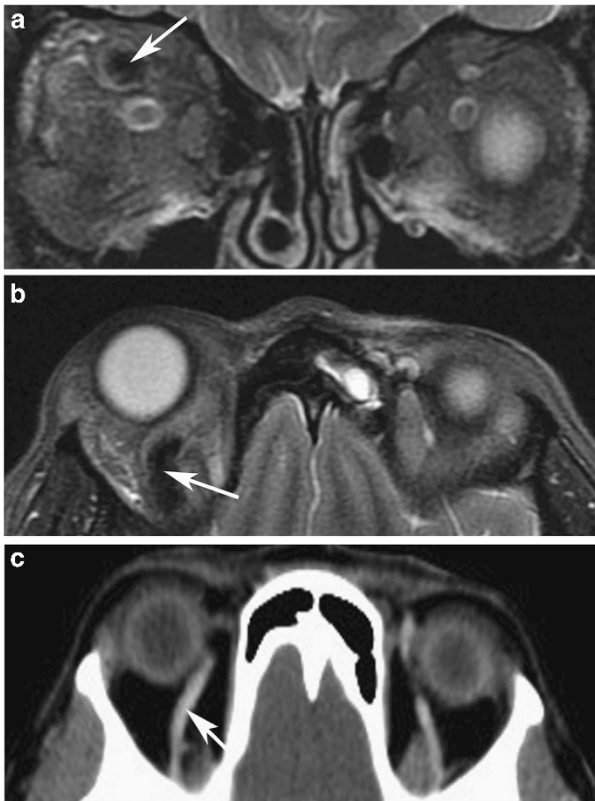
(a and b) Case 1. Axial and coronal MRI and MRV showing intraluminal thrombosis and dilation of the right SOV (arrows). (c) Case 1. Axial CT angiogram showing resolution of SOV thrombosis 4 months later (arrow).
